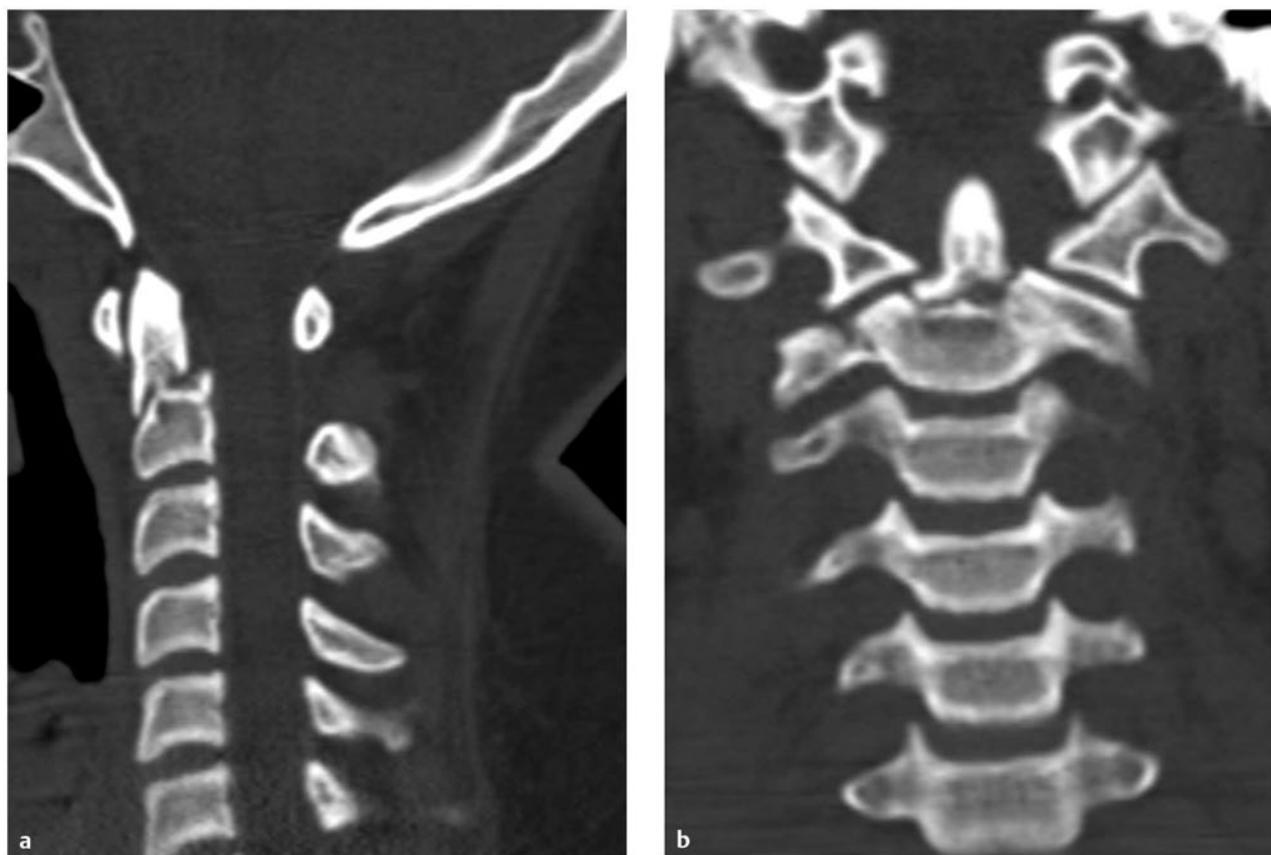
Odontoid fracture. (a) Sagittal and (b) coronal computed tomographic scans demonstrating a type II odontoid fracture in an 18-year-old young man following a motor vehicle accident. Odontoid fractures in children are most commonly actually epiphysiolysis at the dentocentral synchondrosis (which is located slightly below the base of the dens in the rostral C2 body) rather than true odontoid fractures. The patient was successfully treated with halo ring immobilization.
